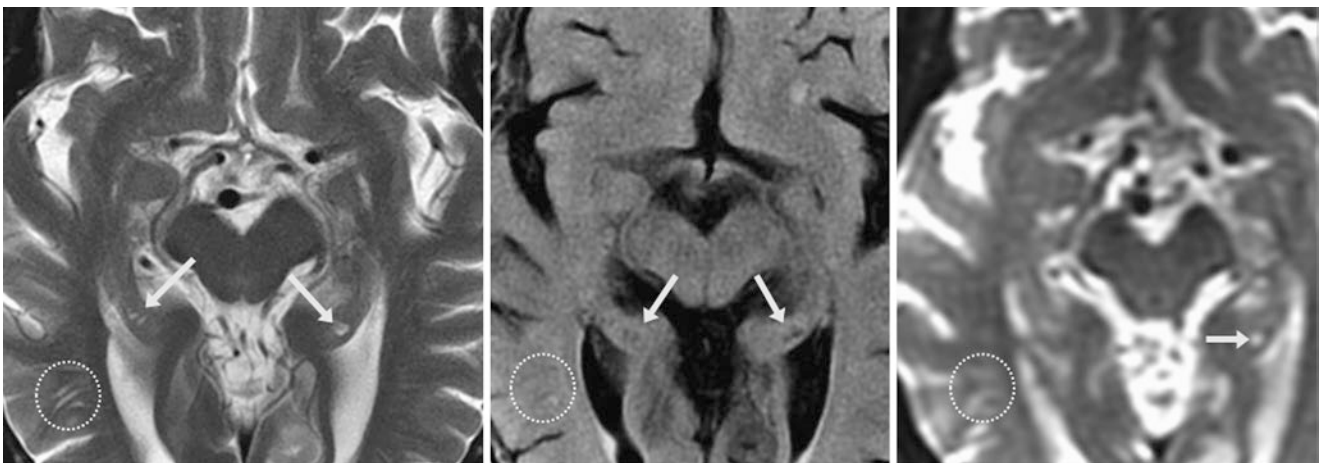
A 73 year old was tested with an axial T2WI MRI (*left*) that demonstrated a small left hippocampal cyst and much smaller cysts on the right (*arrows*). These have a signal intensity of CSF on FLAIR
